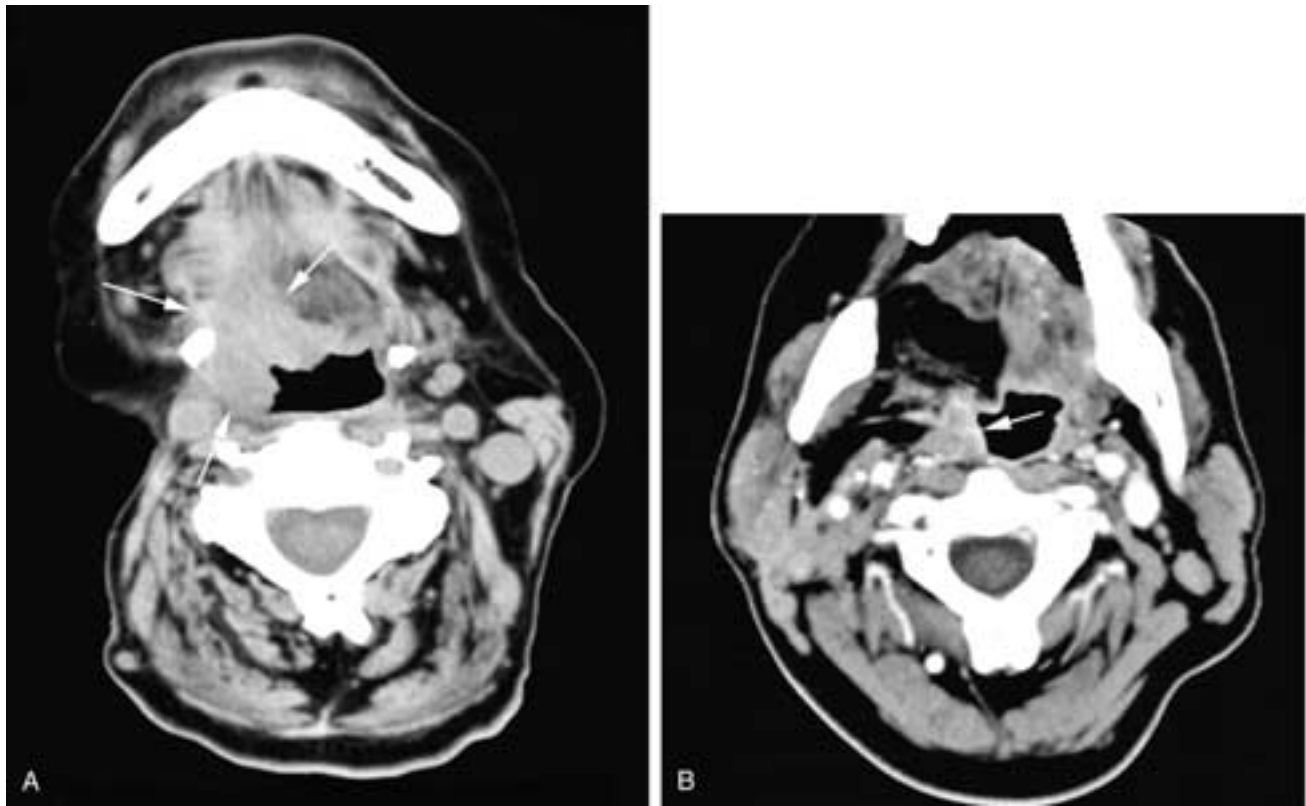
Axial CT contrast-enhanced scan (A) on a patient who has had a partial right glossectomy and a right neck dissection. There is a large recurrence of squamous cell carcinoma within the operative bed (*arrows*). Axial contrast-enhanced CT scan (B) on a different patient who has had a right partial glossectomy and pharyngectomy with flap reconstruction. Along the upper posterior operative margin is a soft-tissue nodule (*arrow*) that was a recurrence of squamous cell carcinoma.
